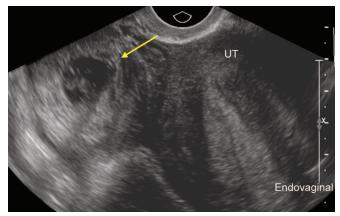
Transvaginal ultrasound of the right adnexal mass (pointed by an arrow). An empty uterus with thickened endometrium is visualized to the right
